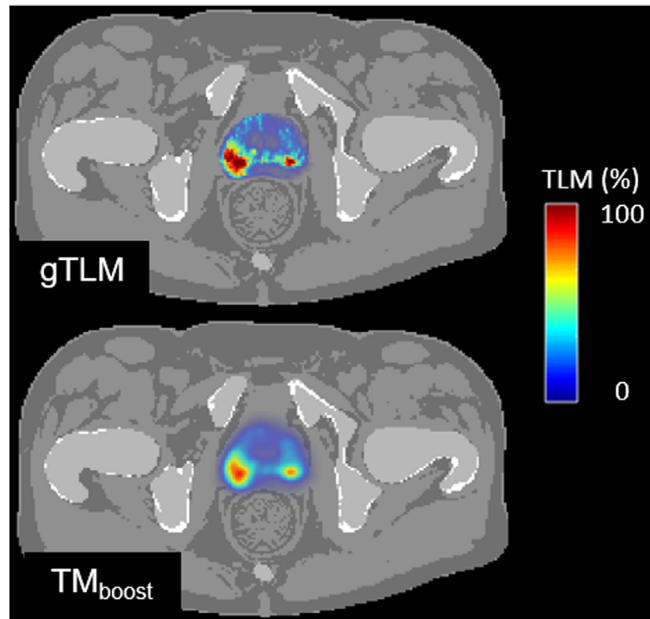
Axial slices of target map used for dose boosting (TM_{boost}). In this case, target volume was smoothed using a gaussian filter reduce the spatial variation observed in the MRI to a level comparable to the resolution of a treatment delivery system, while still being fine enough to retain target sub-volume heterogeneity.
